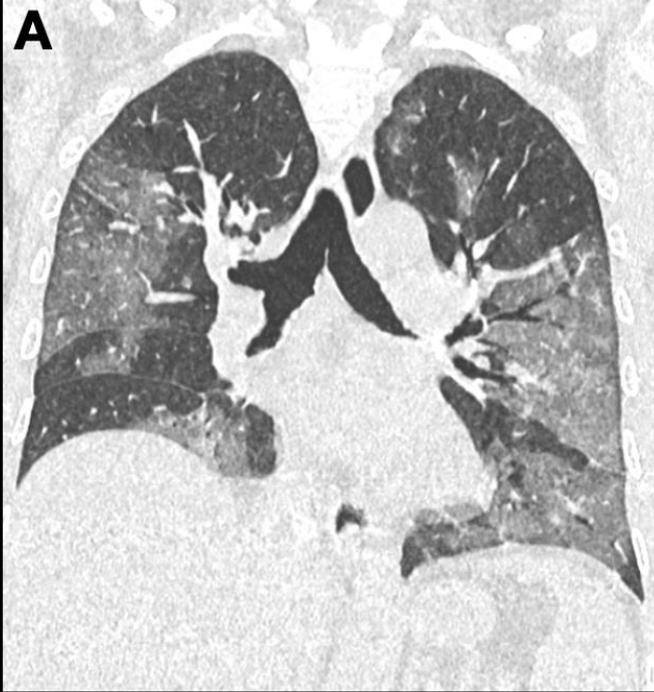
HRCT image of the chest in a patient with mild fibrotic lung lesions 4 months after hospitalization for COVID-19 compared with that during acute COVID-19.
